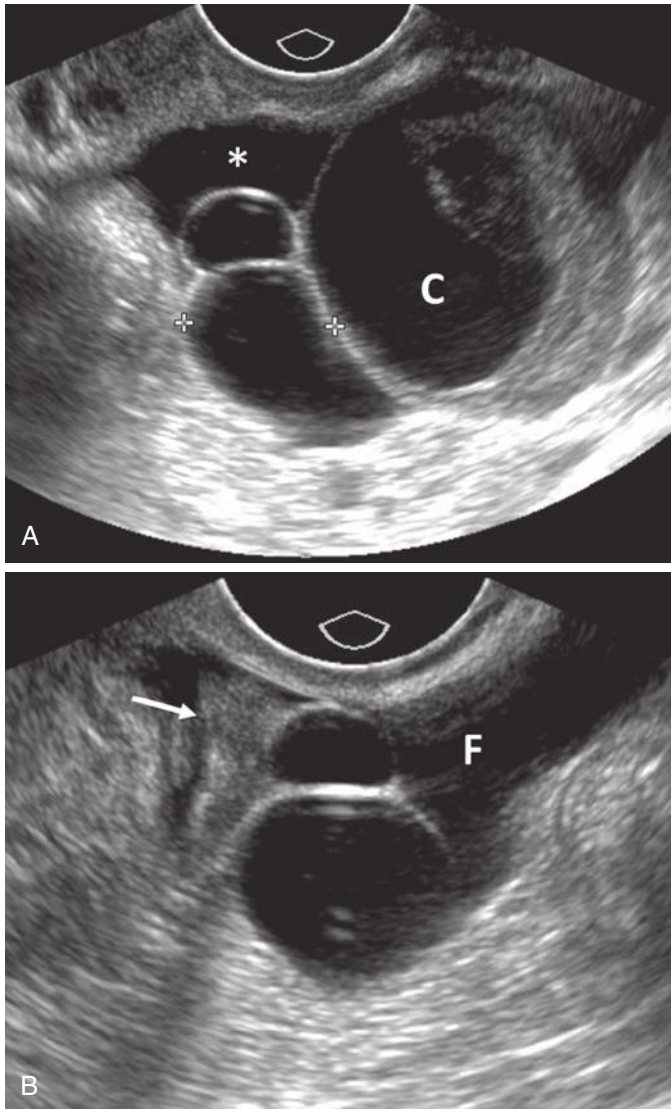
Paratubal cyst. A, Transvaginal sonogram shows a bilobed cystic structure (*calipers*) abutting a hemorrhagic cyst (C) within the adjacent ovary. Note small amount of free fluid anteriorly (asterisk). B, An image obtained slightly more lateral than the plane of image in A demonstrates that the bilobed cyst abuts the fallopian tube (*arrow*), which is outlined by pelvic fluid (F). Although the bilobed configuration is slightly atypical, this lesion proved to be a paratubal cyst.
